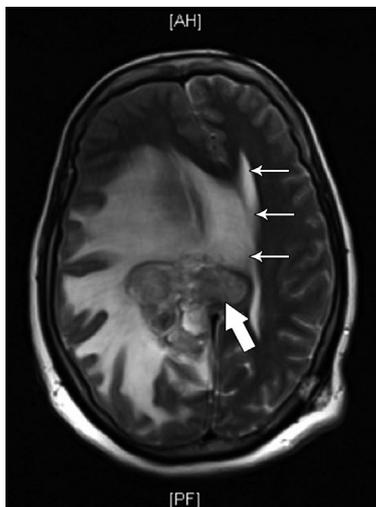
Brain MRI showed significant increase in the size of the right posterior parietal glioblastoma multiforme (wide arrows) with increase in the right to left subfalicine (narrow arrow), and uncus herniation (not shown).
